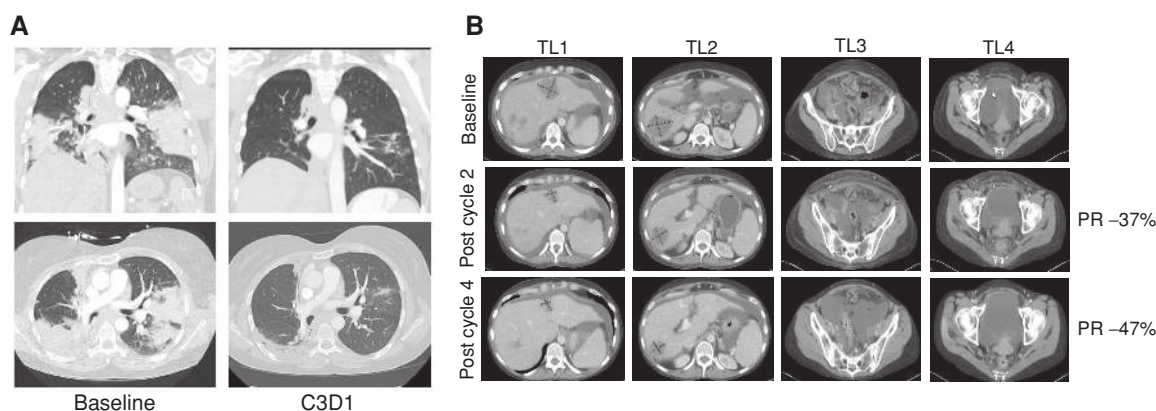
Activity of MRTX849 in patients with lung and colon cancers. A, Pretreatment and 6-week scans of a heavily pretreated patient with a KRAS^{G12C} mutation-positive lung adenocarcinoma indicating 33% reduction of target lesions. Patient continues on study. The top plots show a coronal view, and bottom plots show an axial view of CT chest images prior to MRTX849 treatment (left) and after two cycles of MRTX849 treatment (right). B, Baseline, 6-week (Cycle 2), and 12-week (Cycle 4) scans of a patient with a KRAS^{G12C} mutation-positive colon adenocarcinoma. Partial response (PR) was confirmed at Cycle 4, and patient continues on study. Four lesions (TL1–4) are shown with axial views of CT images prior to MRTX849 treatment (top), after two cycles of MRTX849 treatment (center), and after four cycles of MRTX849 treatment (bottom).
